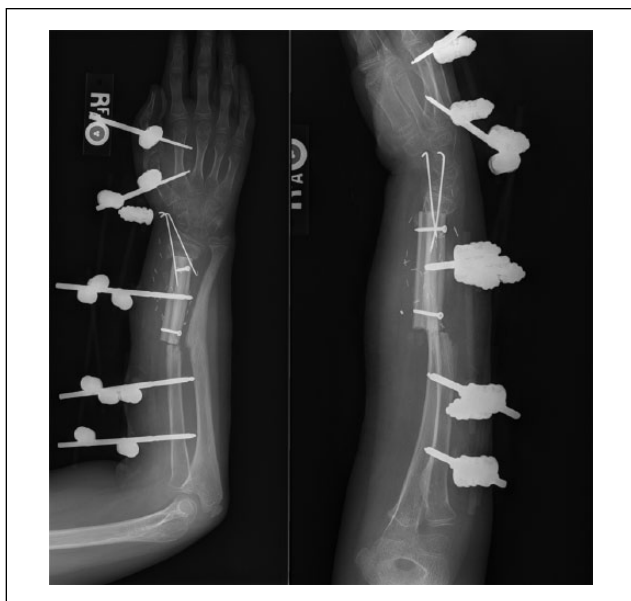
Postoperative radiographs following the open reduction, double-barrow vascularized free fibular graft, and ex-fix placement.
